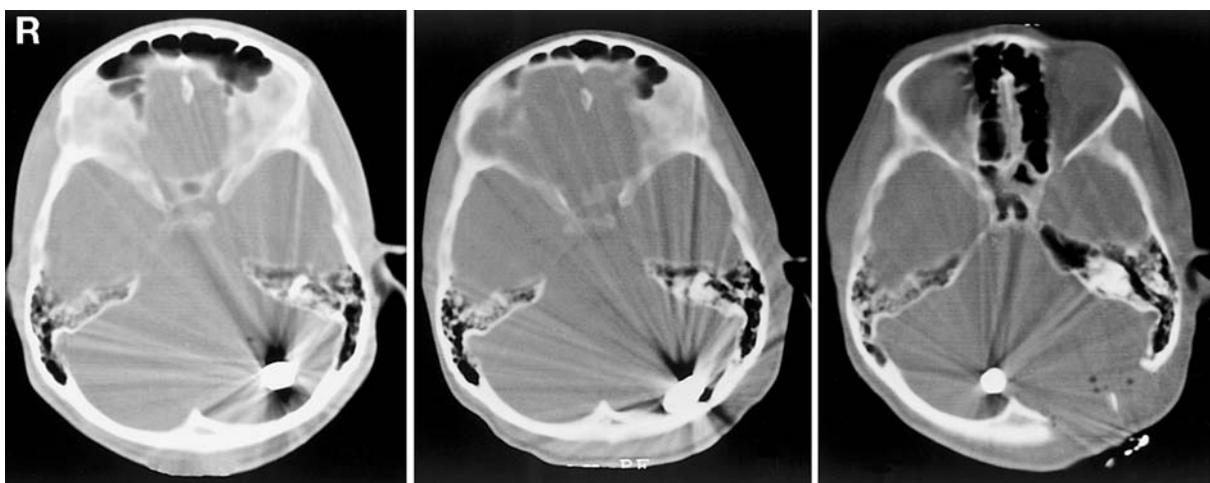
Computed tomography scans showing the bullet in the left cerebellar hemisphere (left) and hemorrhage along its trajectory in the supratentorial brain tissue (right).
